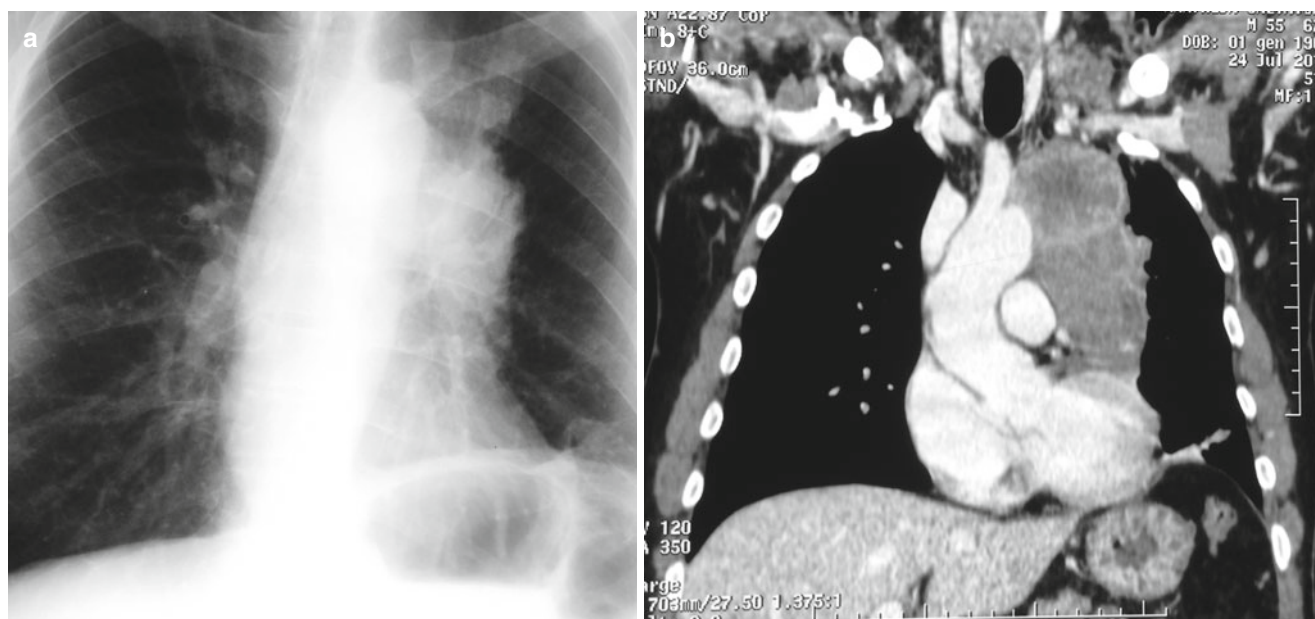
X-ray in AP view (a) and CT (b) of the chest showing a left Pancoast's tumour
